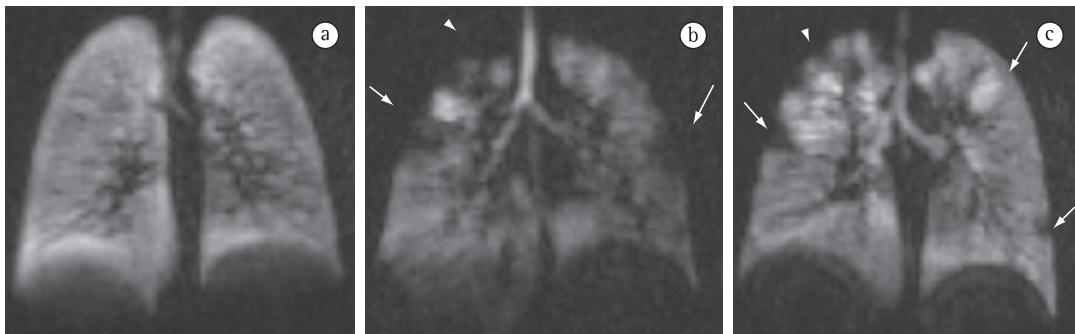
Volumetric magnetic resonance images after inhalation of hyperpolarized helium showing cystic fibrosis in the coronal plane in three different young patients with cystic fibrosis, all of whom presented normal spirometry results. One of the patients presents normal test result (a), whereas the remaining two (b and c) present with peripheral areas of ventilatory defects, some of which are wedge-shaped (arrows), whereas others are irregular and located in the upper lobes (arrowheads). Images kindly provided by Yannick Crémillieux et al.⁽³²⁾ and used with the permission of the Radiological Society of North America.
